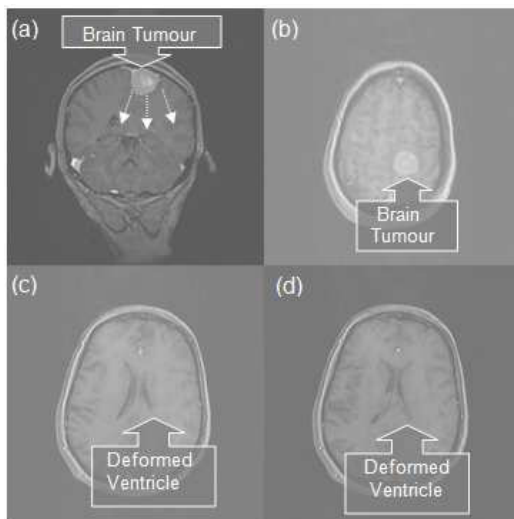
Some selected MR image slices of one patient showing brain tumour and deformed lateral ventricles not in the same plane of axial view [11]: (a) coronal view in middle of the head; (b) axial view from slice near the top area of the head; (c) axial view from slice in the middle area of the head; (d) axial view from slice next to (c).
